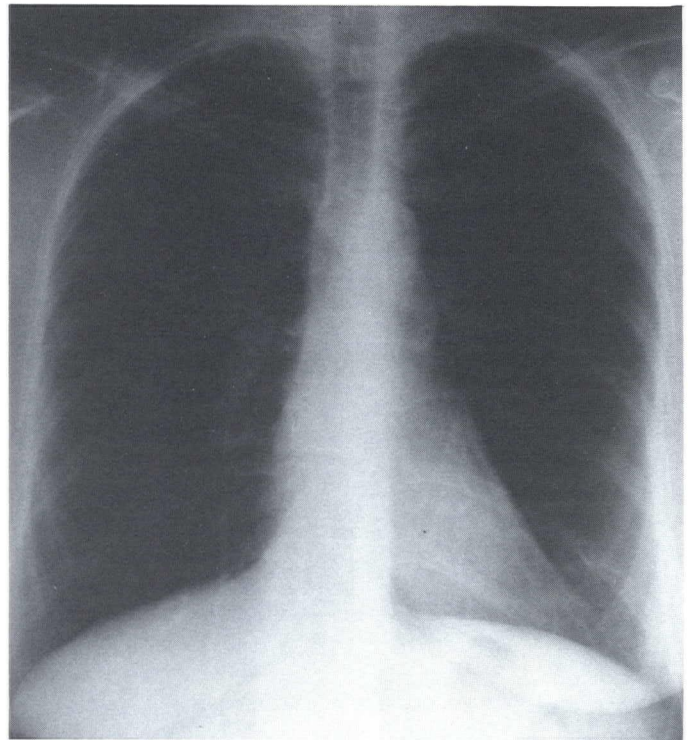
Follow-up chest x-ray showing resolution of left pleural effusion.
